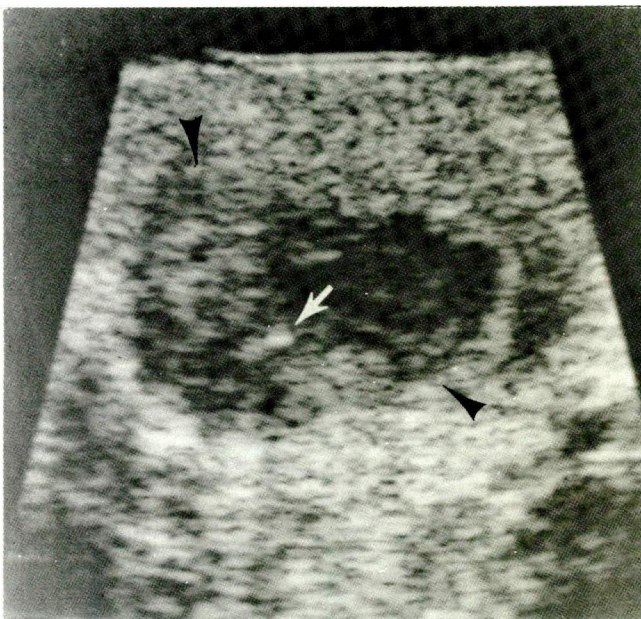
Tumor recurrence in the postorchietomy space. A 27-year-old male status one month postorchietomy for mixed germ cell tumor invading the capsule and epididymis. There were also retroperitoneal metastases. A 1.5cm nodule was palpable in the right sac. Saggital sonogram shows a 1.5cm hypoechoic mass (arrowheads). Notice small calcification (arrow). Following chemotherapy, both the nodule and retroperitoneal nodes regressed.
